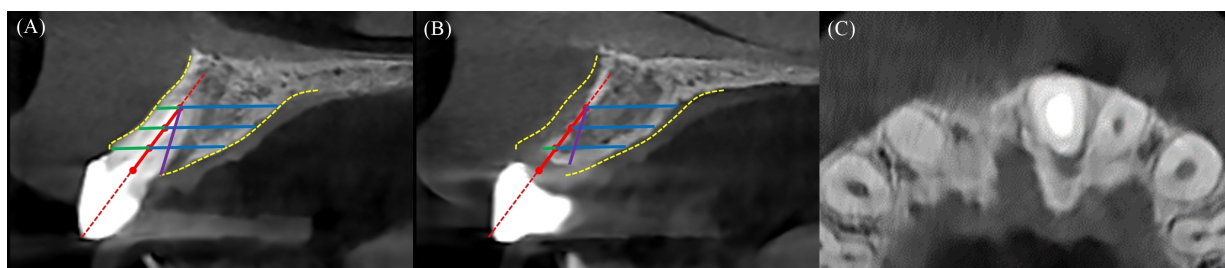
CBCT images of (A) #11 and (B) #21 10 years after surgery. Yellow: outline of alveolar bone; red: long axis of the tooth (the crestal, middle, and apical points were placed 3 mm, 6 mm, 9 mm from CEJ, respectively, and lines parallel to the FH plane were drawn at each point); green: labial bone width; blue: palatal bone width; and (C) purple: alveolar height, measured from the apical point to the palatal alveolar crest. (C) CBCT axial view.
